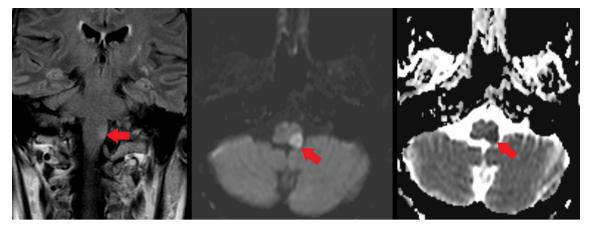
MRI demonstrating an infarct in the left posterior lateral aspect of the medulla (left: coronal fluid attenuation inversion recovery sequence; middle: axial diffusion weighted imaging; right: accompanying apparent diffusion coefficient image).
